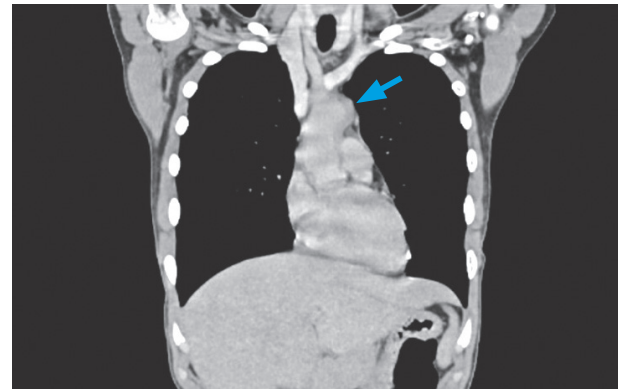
Thoraco-abdominopelvic computed tomography scan revealing a concentric parietal aortic thickening of the ascending aorta and aortic arch (arrow).
